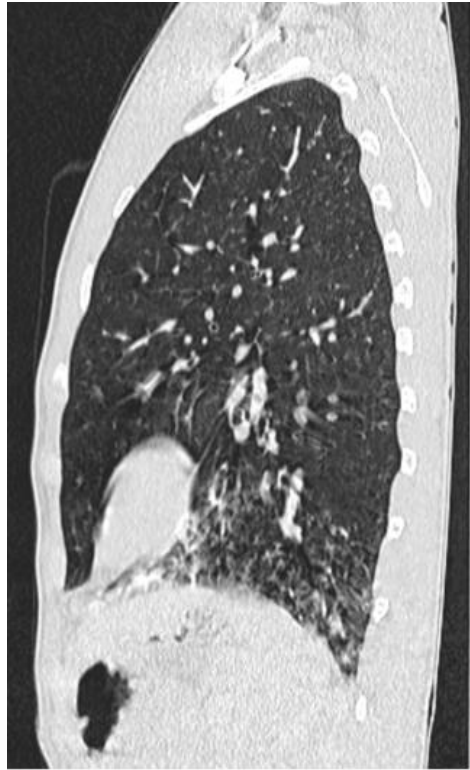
Computed tomography: signet ring sign (bronchiectasis)
